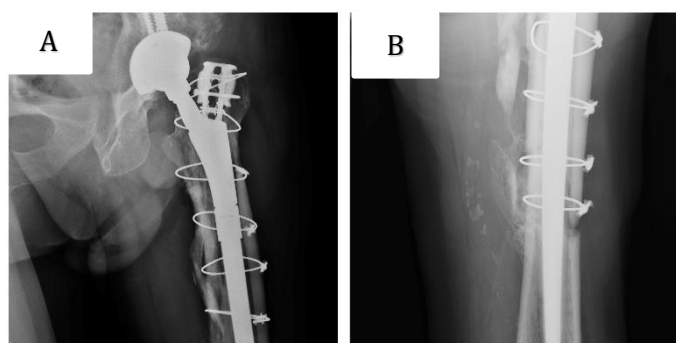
Radiographic anteroposterior (A) and axial view (B) at three months of follow-up showing the partial healing at the fracture site, the adequate position of the implant, and no signs of migration
